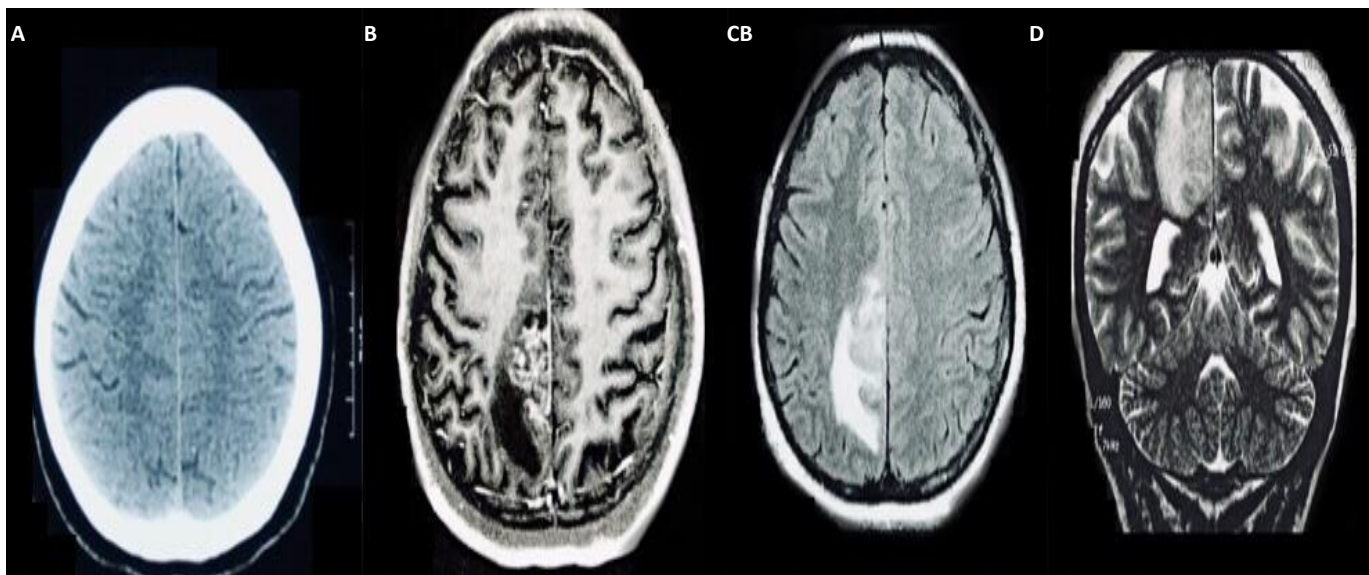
Brain CT with no radiological findings (A). One month after MRI showing in B an enhanced fronto-parietal lesion with high signal in flair (C) and T2 image (D).
